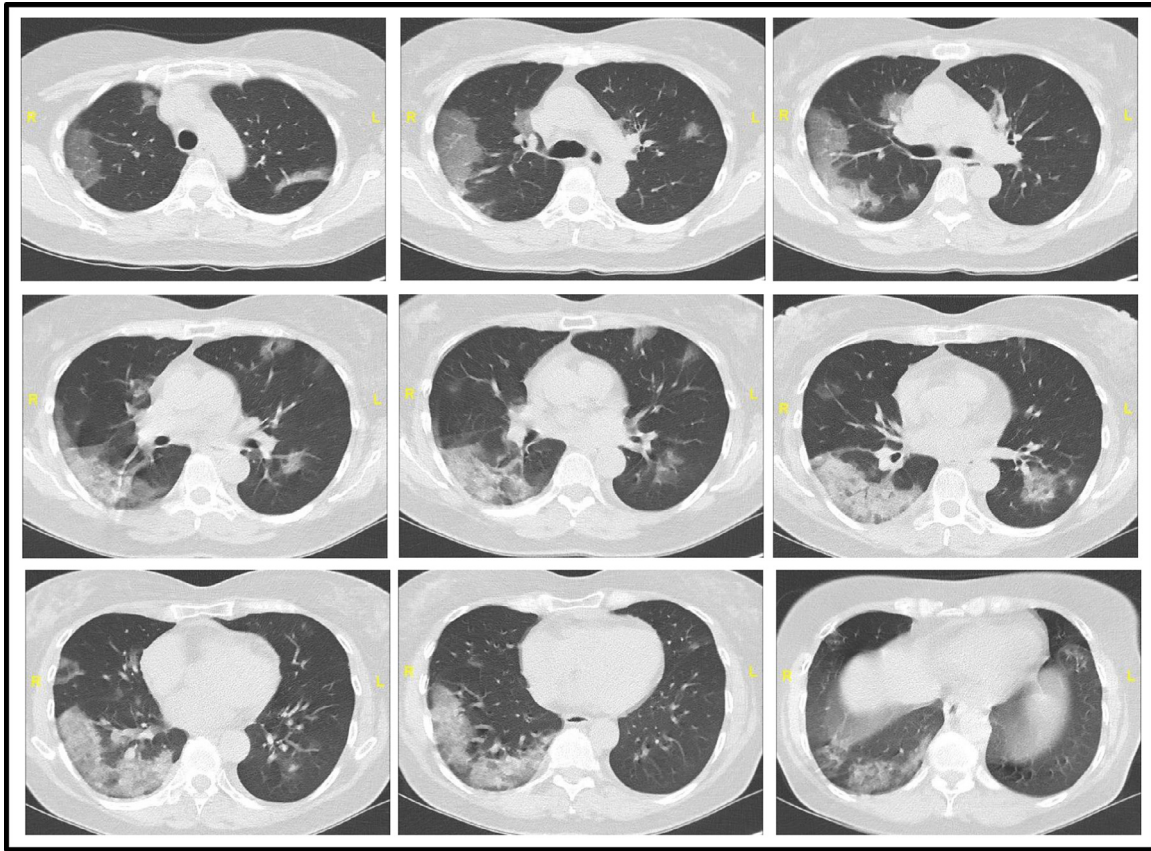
Chest CT images. Chest CT imaging showed bilateral, multiple ground-glass opacities with a peripheral lung and subpleural distribution in the upper and lower lobes.
